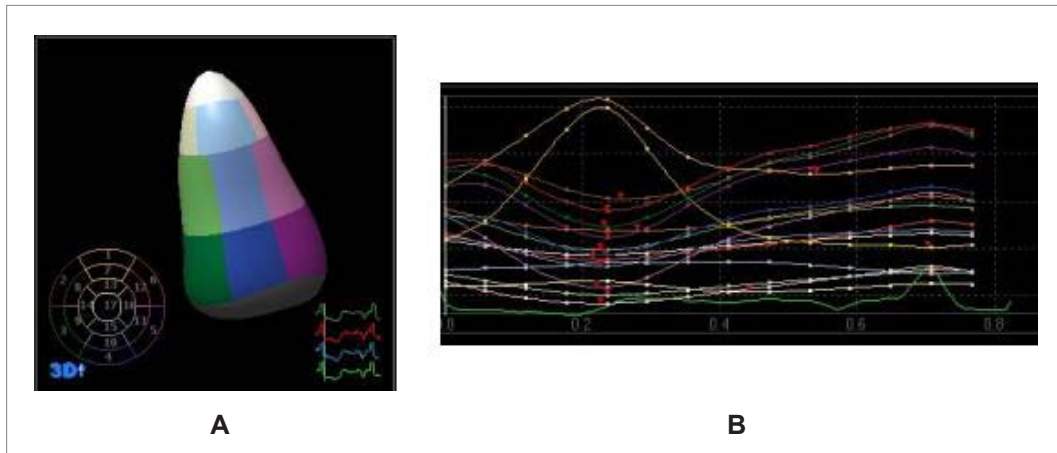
3D echocardiography – segmentation of the left ventricle (a) and wall motion analysis (b) using contractility curves for each of the 17 segments
